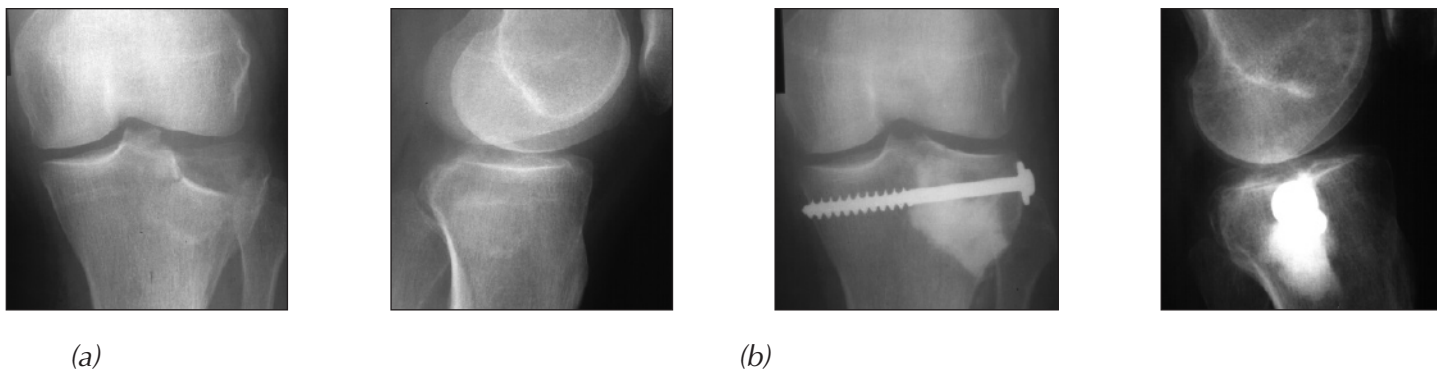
(a) AP and Lateral radiographs, 67-year old female with depressed fracture of the lateral tibial plateau. (b) AP and Lateral radiographs 12 months after ORIF with filling the defect with Norian® SRS® (Synthes USA, Paoli, PA). No loss of reduction of the plateau surface is noted, fracture completely healed.
